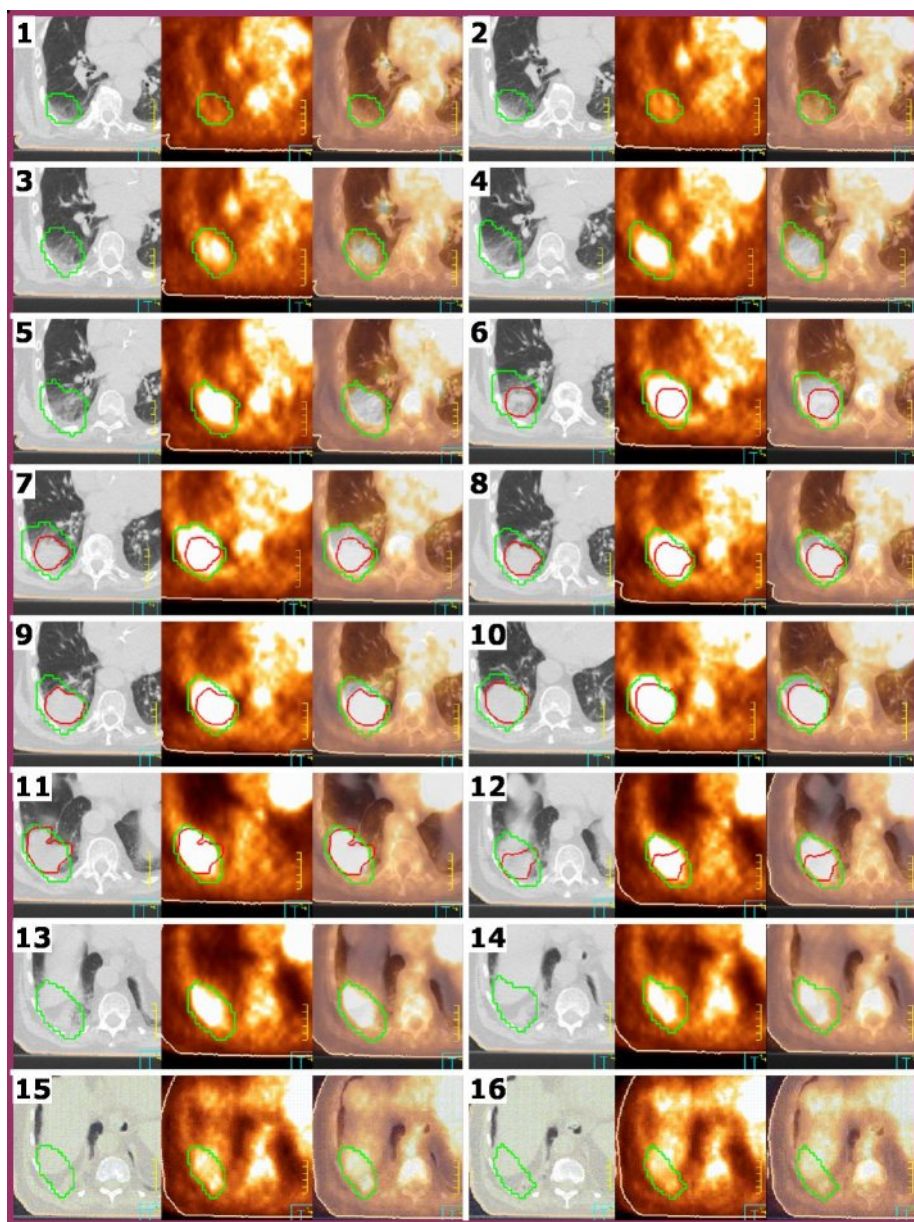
A series of CT, PET, and fused PET/CT transaxial slices for lung case one showing the radiologist-delineation (green), the oncologist-delineation (red) and the patient's outline (light-brown).
